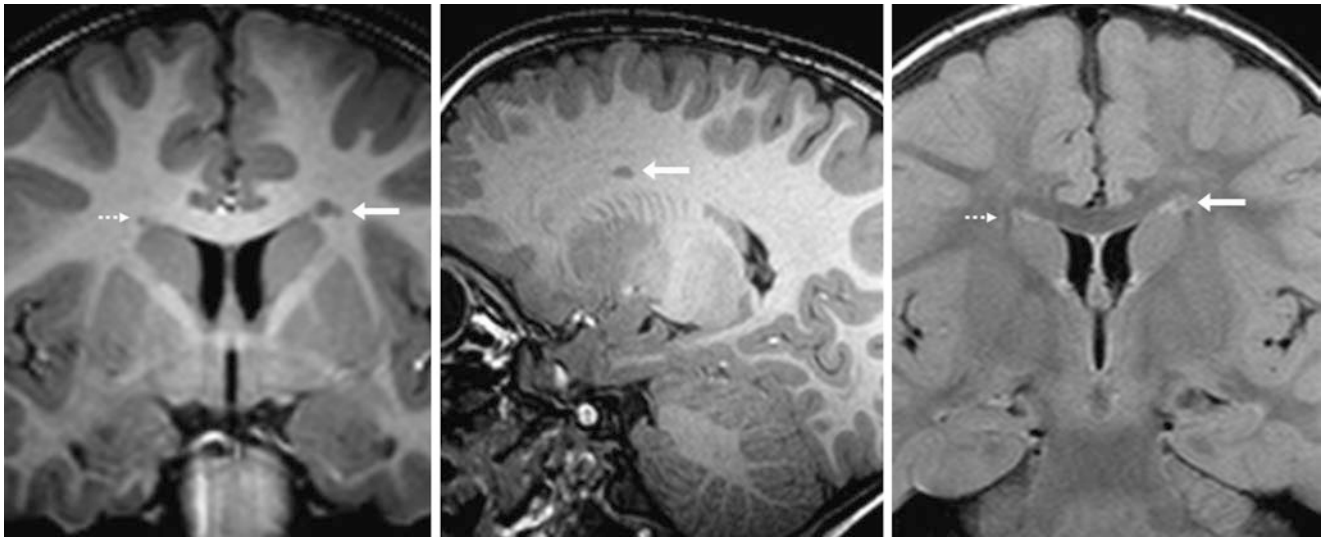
Comparison case of periventricular nodular heterotopia (PVNH). In a 2 year old with seizures, a 3 T MRI demonstrated left PVNH (*arrows*) that appears similar to normal ependymitis granularis on the opposite side (*dashed arrows*) as shown on coronal T1WI (*left*), sagittal T1WI (*middle*), and coronal FLAIR (*right*)
